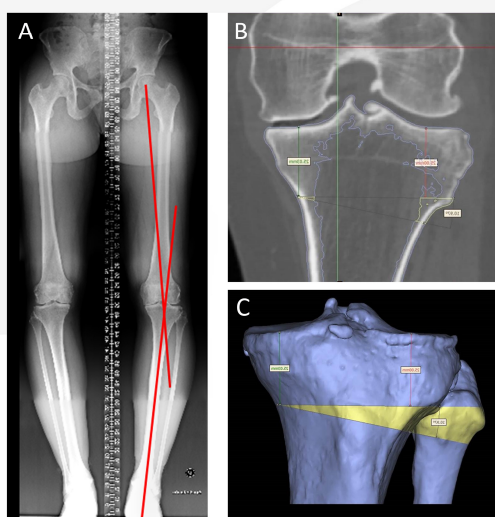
surgical planning using radiographies (A), CT scan images (B) and subsequent 3D reconstruction (C).
